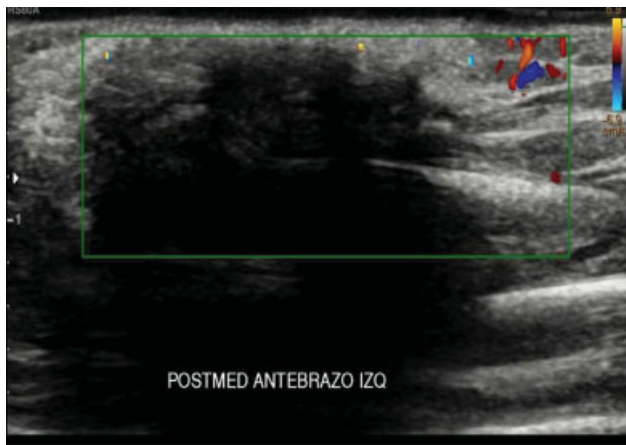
Ultrasound scan of the left forearm: oval focal image, with partially defined contour, with posterior acoustic shadow, which does not show flow on Doppler. Abbreviation: POSTMED, postmedication.
